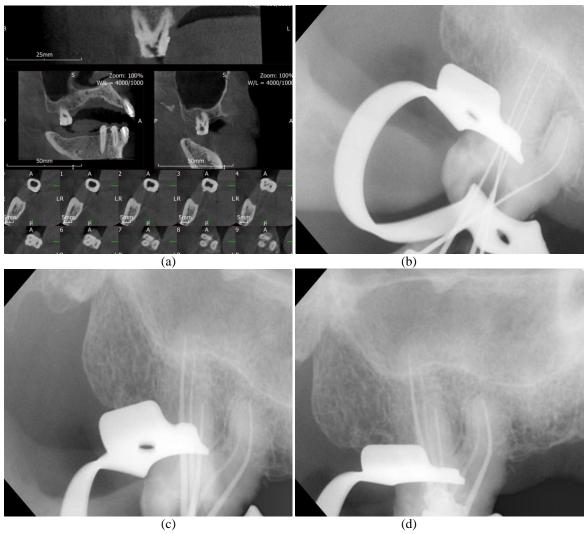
a) CBCT showing axial section and saggital section of tooth presenting 3 roots 5 canals (17). b)radiograph showing working length determination c) radiograph showing master apical file. d) radiograph showing obturation
